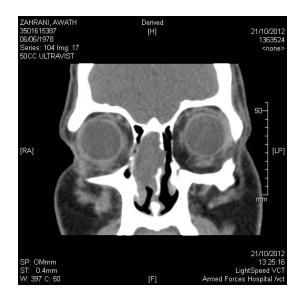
CT scan of PNS coronal view showing the right ethmoid mucocele.
